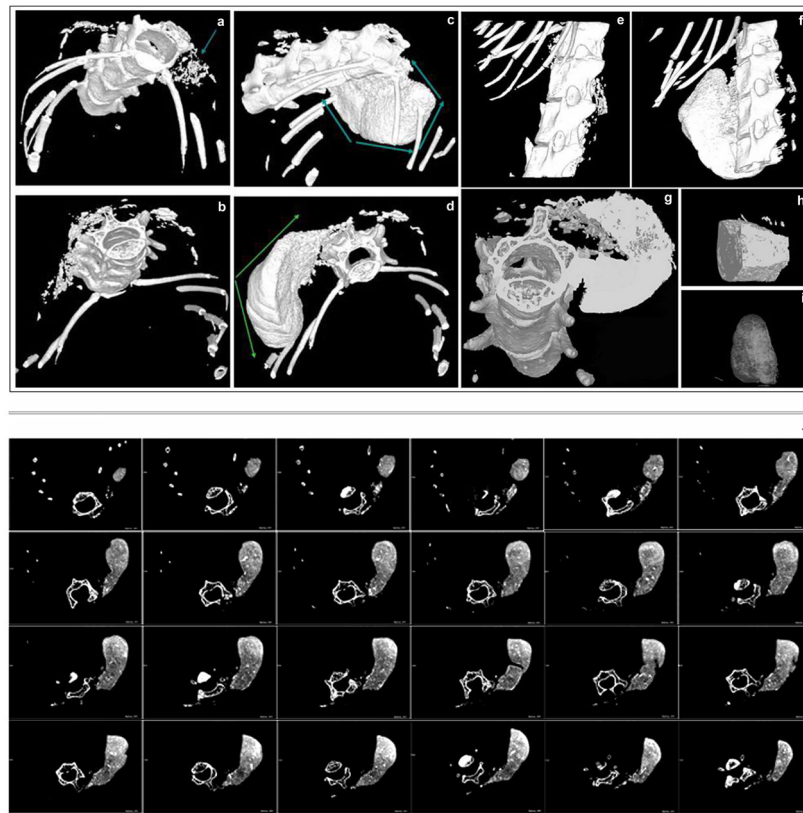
μ CT analysis and 3D reconstruction of the extent of ectopic bone formation following implantation of the HA/COL scaffold seeded with adenoviral transduced dermal fibroblasts into the paravertebral muscle
